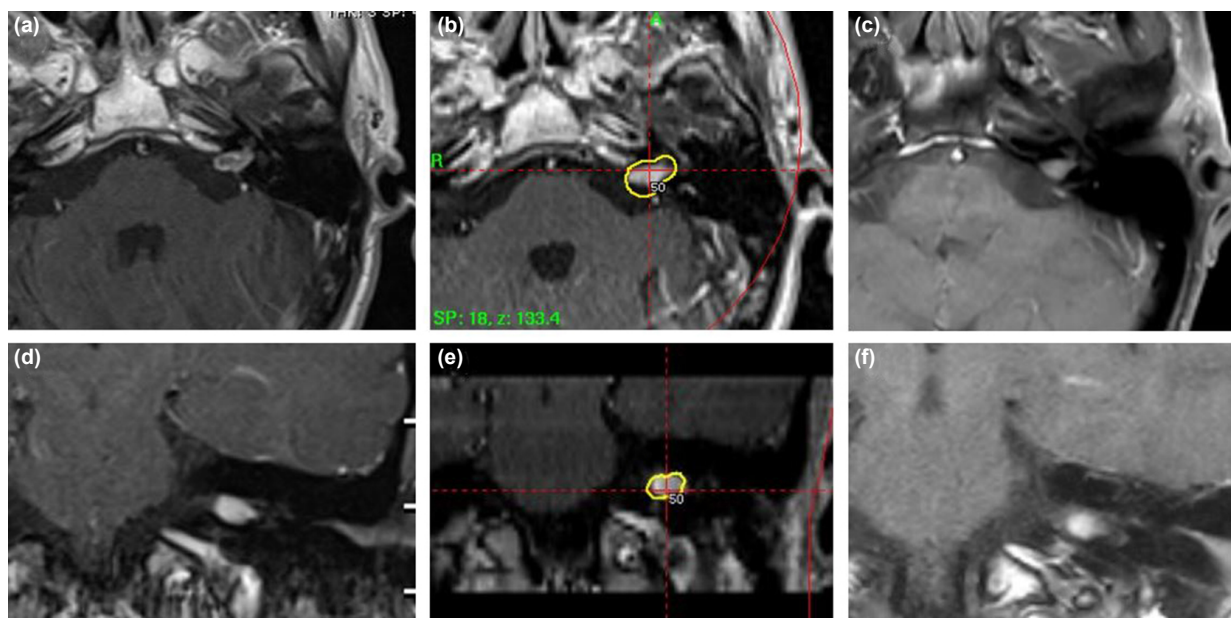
Radiological imaging documentation of 2 index patients. Upper row, 70 years old, male patient, 83 months follow-up duration, magnetic resonance imaging (MRI). (a) At the time of diagnosis. (b) On the day of treatment. (c) At the time of the last follow-up. Lower row, 50 years old, female patient, 117 months of follow-up duration, MRI. (d) At the time of diagnosis. (e) On the day of treatment. (f) At the time of the last follow-up.
